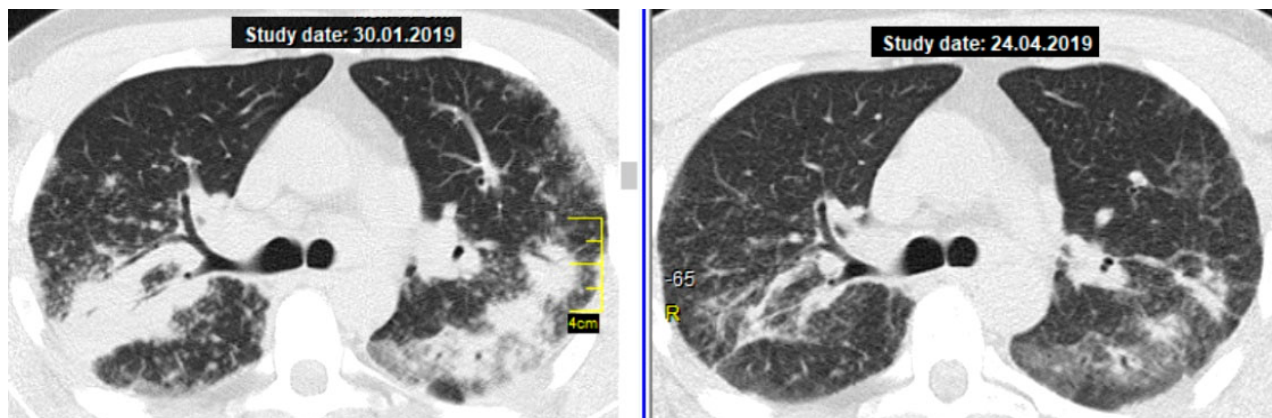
Patient S., age 27, pulmonary sarcoidosis, stage II, atypical form - multiple massive consolidations in both lungs, respiratory failure (MRC 3); CT of TO (axial slice at the level of tracheal bifurcation): on the left - before treatment, on the right - regression after 3 months of treatment with MT (15 mg/week)
